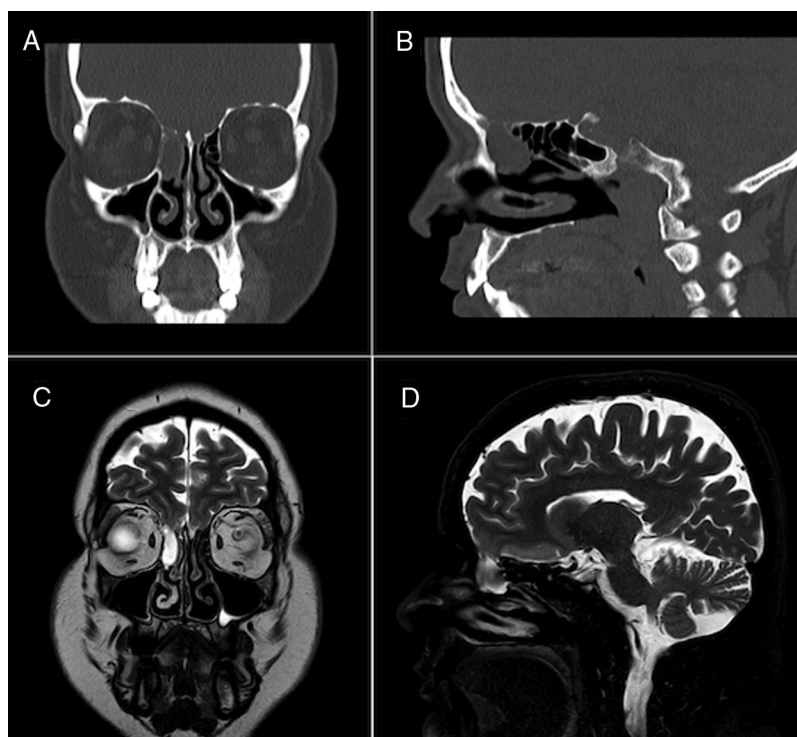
Coronal (A) and sagittal (B) face CT scans revealing a hypodense mass in the right anterior ethmoidal air cells and a defect in the ipsilateral cribriform plate. Coronal (C) and sagittal (D) brain MRI sequences confirming these findings and ruling out myelomeningocele.
